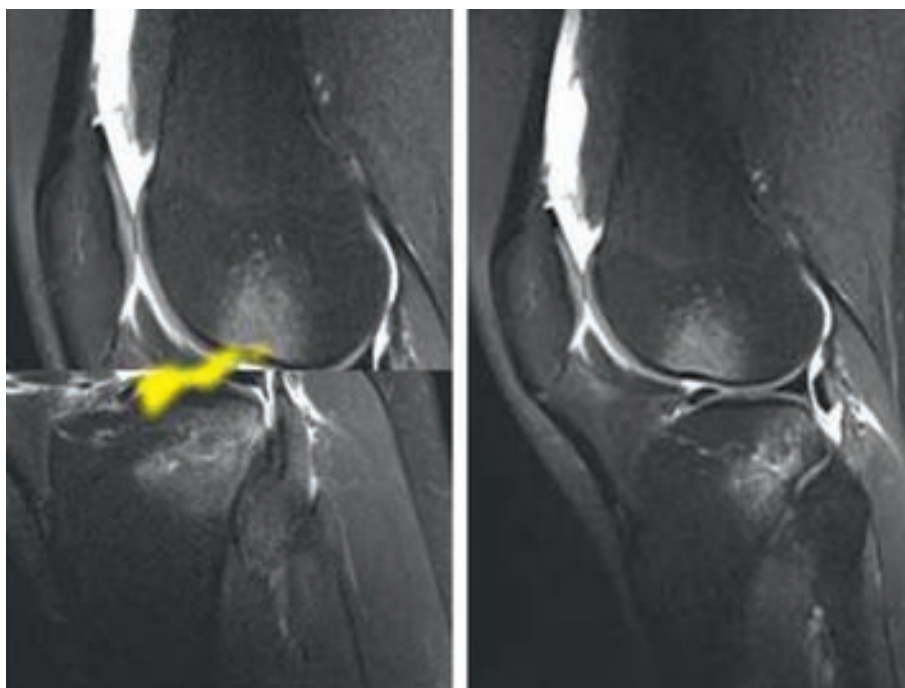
MRI scan views of right knee joint showing injury mechanism, with posterior translation of femur leading to ACL tear and characteristic bruising pattern.
